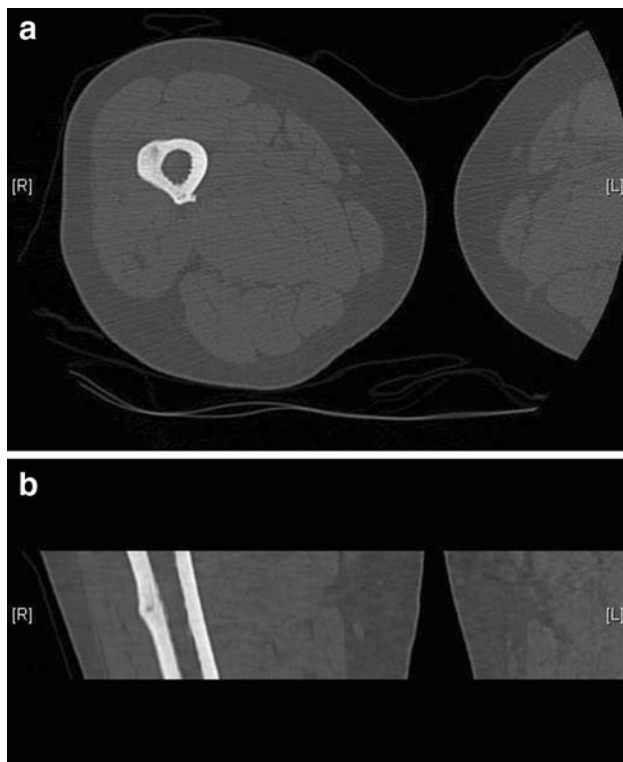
CT scan of the right femur showing the lytic lesion in axial (a) and coronal (b) plane
